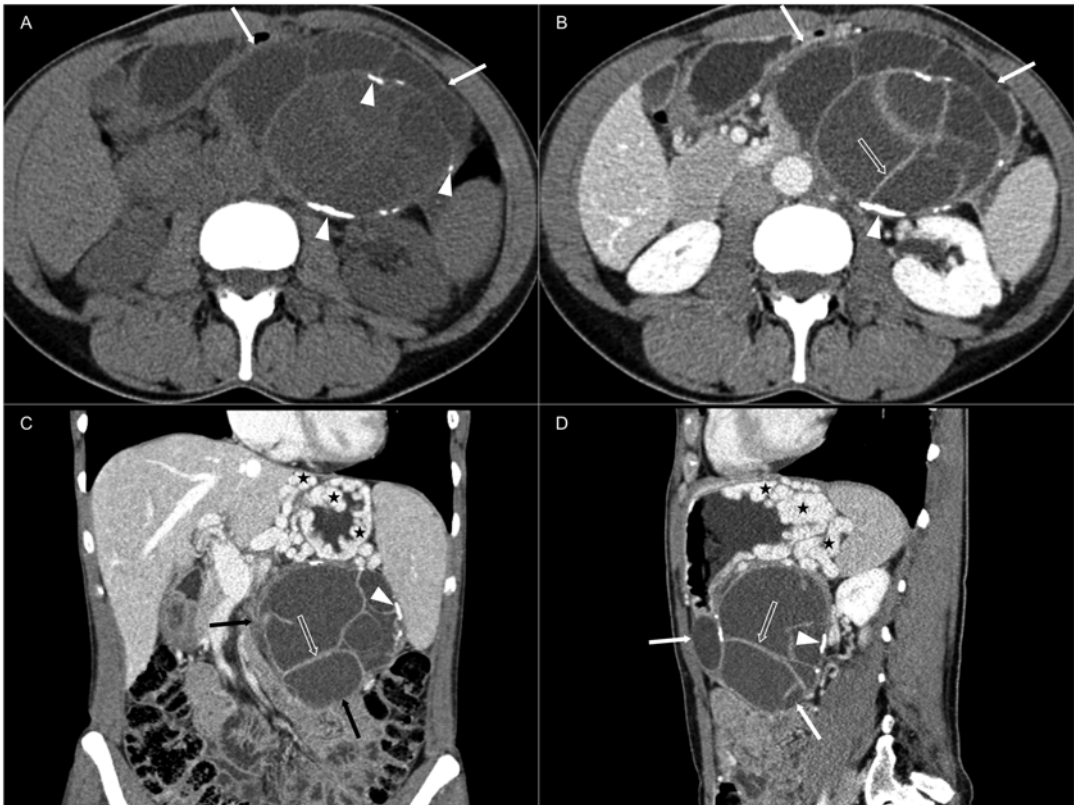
Imaging features of a female patient with a large mucinous cystic neoplasm at the pancreatic body and tail on unenhanced (a) and contrast-enhanced (b–d) CT. The lesion (*arrows*) is multilocular, has peripheral and septal calcifications (*arrowheads*), and has relatively thick, contrast-enhancing internal septations (*open*
